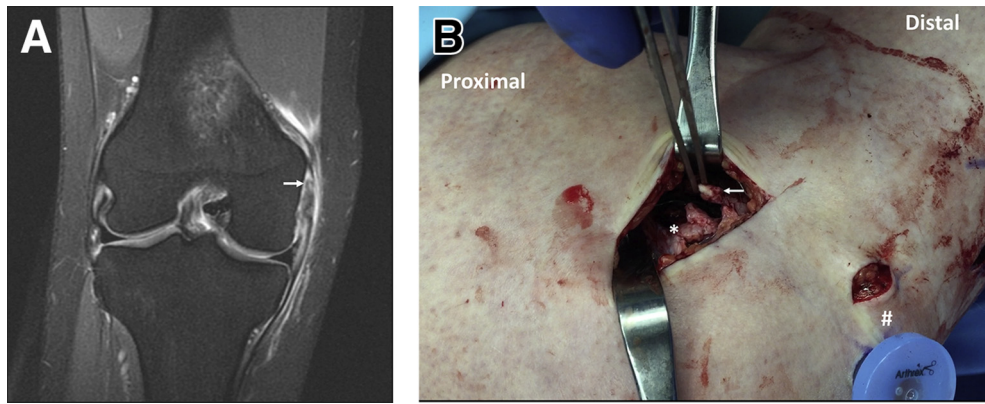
(A) Coronal T2-weighted image of the right knee showing a femoral tear of the medial collateral ligament (arrow). (B) View on the medial side of a right knee in 90° of flexion. The proximal stump of the medial collateral ligament (asterisk) and the distal avulsed ligament (arrow) can be seen. At the bottom right corner, the PassPort cannula (Arthrex) (hash sign) can be seen from the arthroscopic primary anterior cruciate ligament repair.
